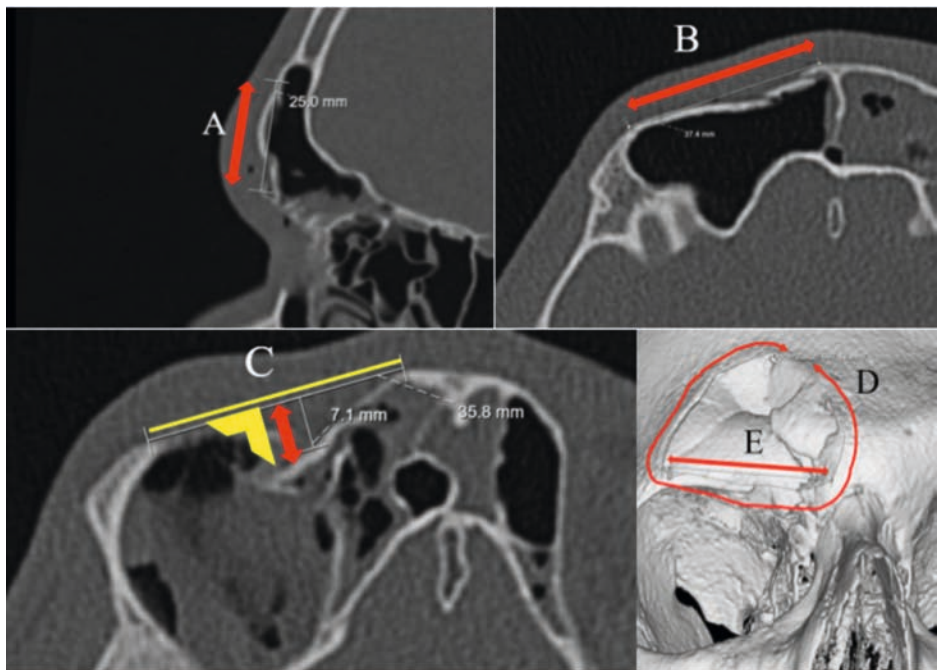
Dimensional fracture measurement properties of a frontal sinus fracture. (A-E) DICOM-viewer CT measurements: (A) length, (B) width, (C) deepest impression point, (D) area, and (E) largest diagonal length.
